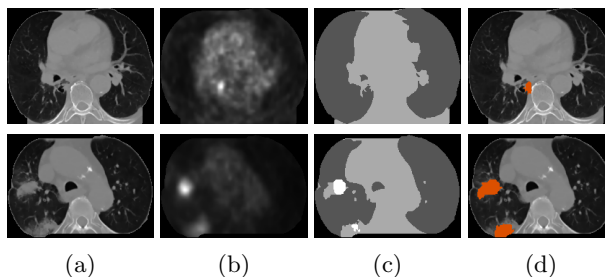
Two example localization outputs. (a) Transaxial CT image slices (showing the thorax after preprocessing). (b) Co-registered PET image slices. (c) The labeling outputs using standard CRF, with dark gray for lung field, light gray for mediastinum and white for lesion. (d) Our localization outputs with the two additional potentials, with lesions highlighted in orange.
